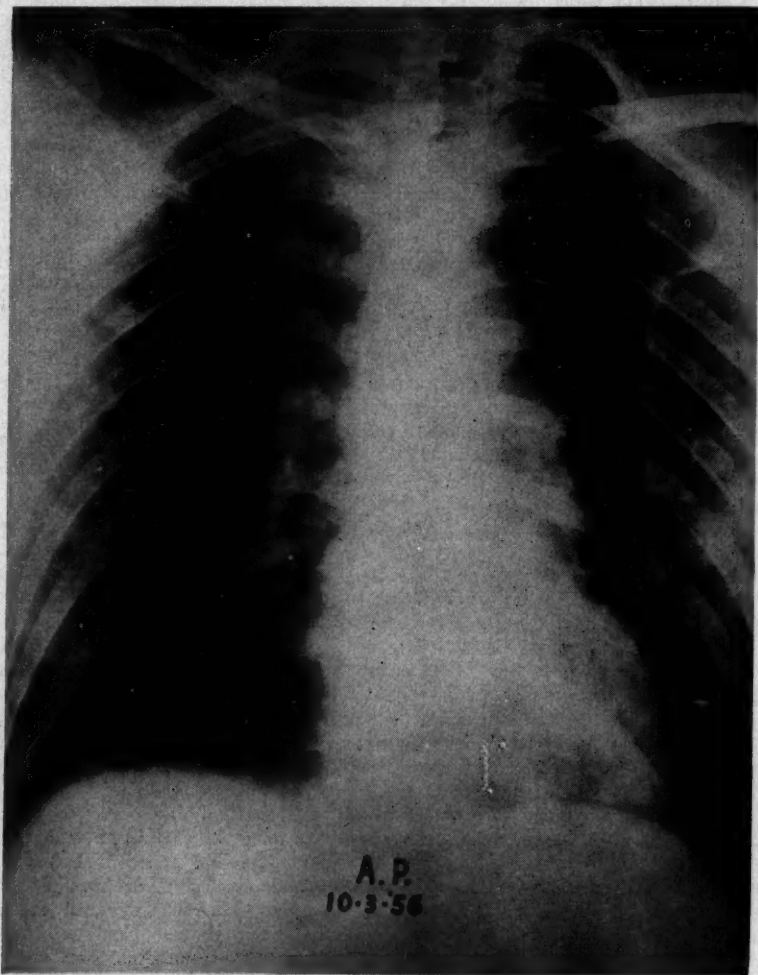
Chest x-ray of case 12 during the acute illness, showing extensive bilateral infiltrative and nodular lesions.
